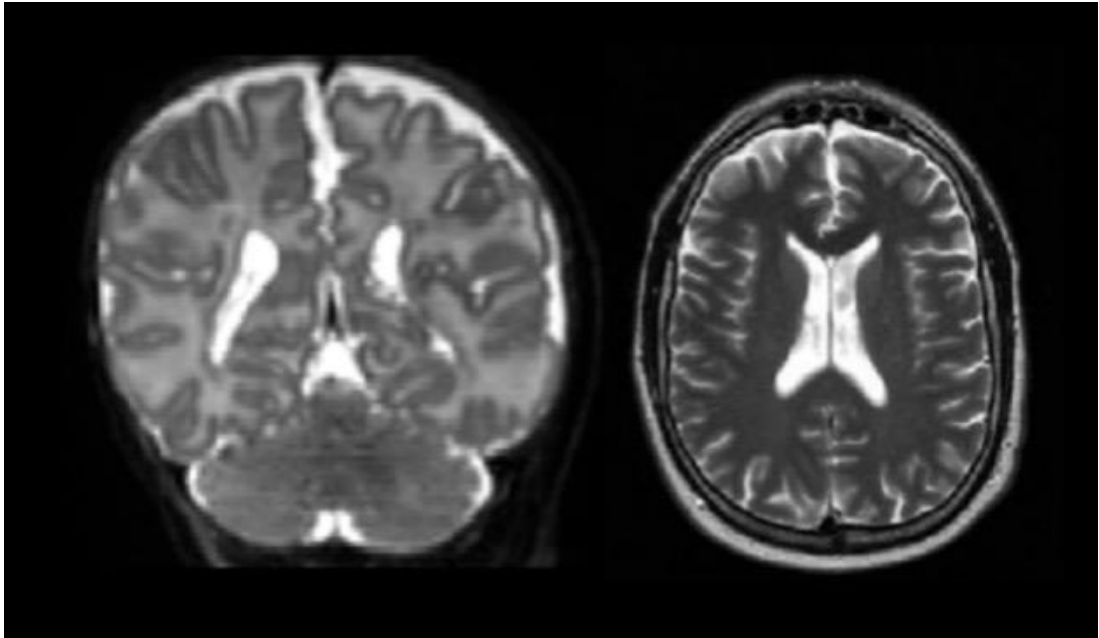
Different contrast of a T2-weighted image according to age of subject: neonatal brain (left) compared with adult (right).
